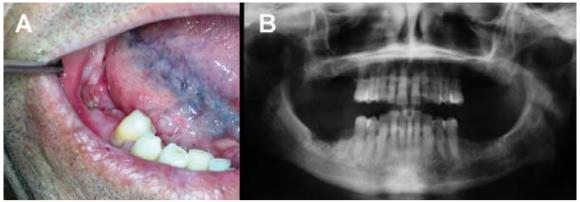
A y B. (A): Intraoral view of nonhealing sockets and mucosa around the 1° and 2° right lower molars, when the patient was sent 6 months after dental extractions, and (B): panoramic x-ray showing initial images of osteonecrosis.
